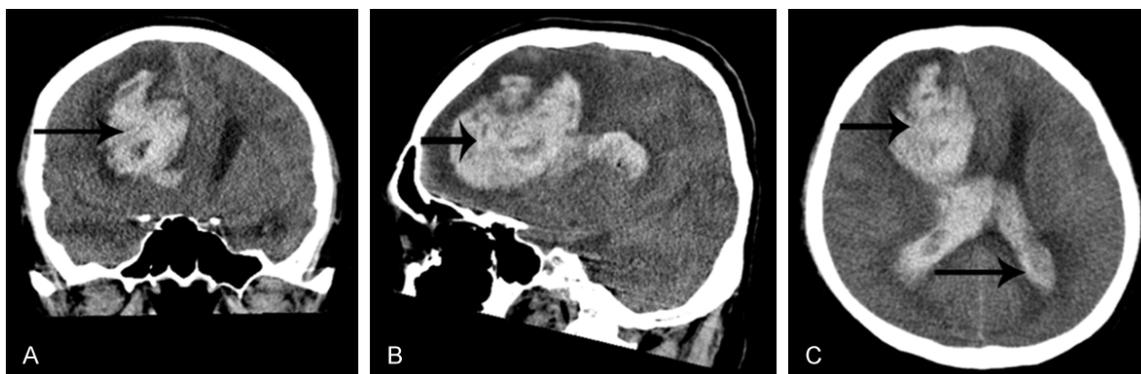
Intracranial CT scan, March 3, 2015. A-C. Show a hemorrhage in the right frontal lobe, breaking into the body of the right ventricle, the third ventricle, the left lateral ventricle angle, the mid-brain aqueduct and the fourth ventricle. A diffuse brain abscess is seen.
